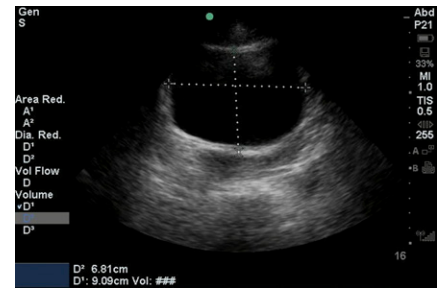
Bladder volume calculation. Many modern ultrasound machines have automated calculation software. To perform the volume calculation, the bladder needs to be imaged in the transverse and sagittal planes. In the transverse plane, the depth is measured, followed by the width. Then, the transducer is rotated with the indicator toward the patient's head to obtain the final measurement in the sagittal plane. Measurements are saved and automatically calculated by software, which accounts for the bladder volume correction factor. The vertical dashed line denotes the depth in the transverse view; the horizontal dashed line represents the width in the transverse view.
